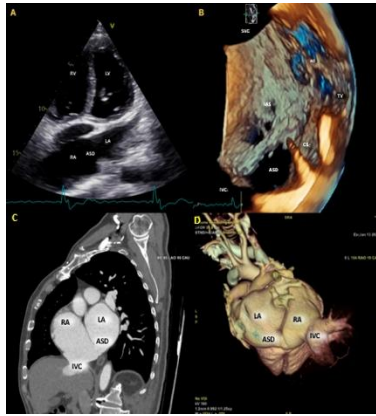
Echocardiogram: A) Modified apical four-chamber transthoracic echocardiogram in the posterior direction to visualize the defect (ASD) and associated anatomical landmarks. B) Transesophageal echocardiogram with three-dimensional reconstruction, viewed from the right atrium of the interatrial septum, to identify a sinus venosus-type atrial septal defect (ASD) and associated anatomical landmarks. Cardiac CT angiography: C) Multiplanar reconstruction showing an inferior atrial septal defect adjacent to the inferior vena cava. D) 3D reconstruction of the defect with adjacent anatomical landmarks.
